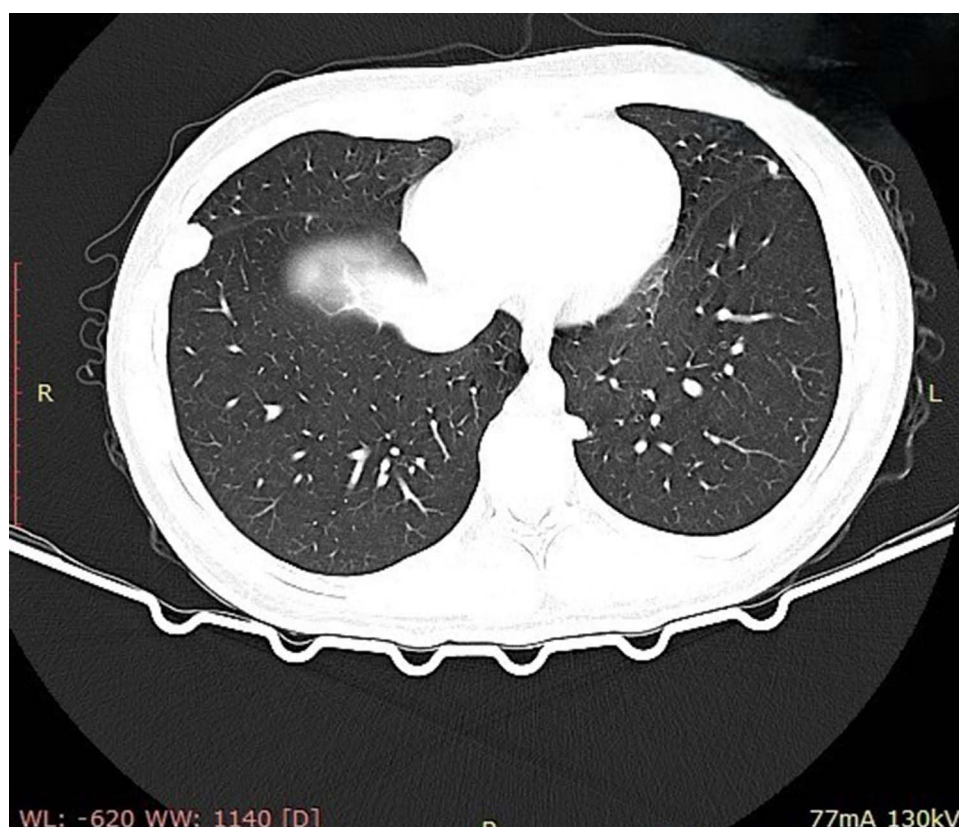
Additional axial chest computed tomography (lung window) demonstrating representative bilateral pulmonary nodules (including a pleural-based/right lower lung lesion), further supporting pulmonary metastases at diagnosis.
